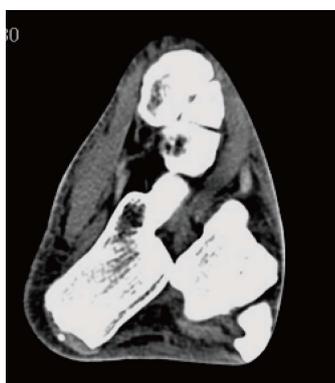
Transverse plane computed tomography image of the patient's left ankle demonstrating the subtalar dislocation without any associated fracture.
